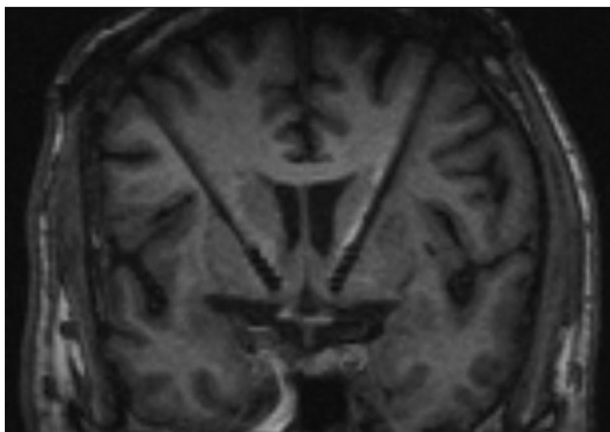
Axial oblique T1-weighted magnetization-prepared rapid gradient-echo image that is in-plane with bilateral deep brain stimulation electrodes targeting the ventral striatum/anterior limb of the internal capsule. The deeper contacts include the nucleus accumbens. The four electrode contacts are seen as small rounded enlargements at the end of the electrodes.
